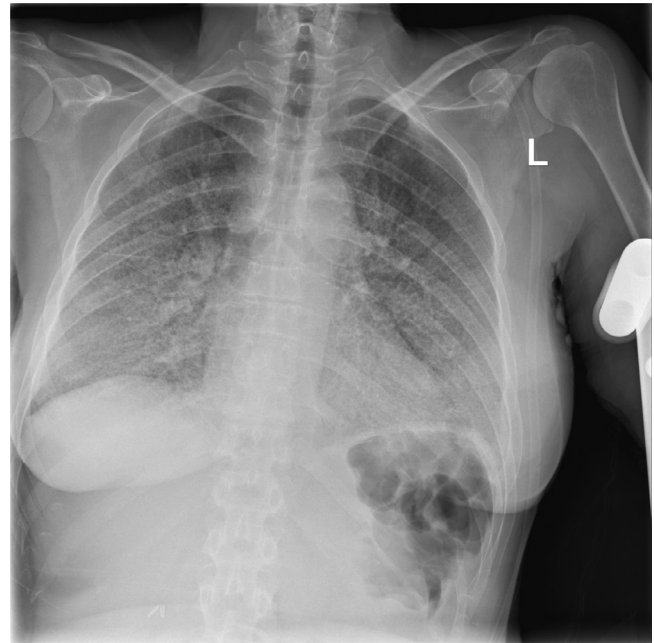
(Patient 1): Admission chest x-ray showing bilateral patchy infiltrates consistent with COVID-19 infection.
